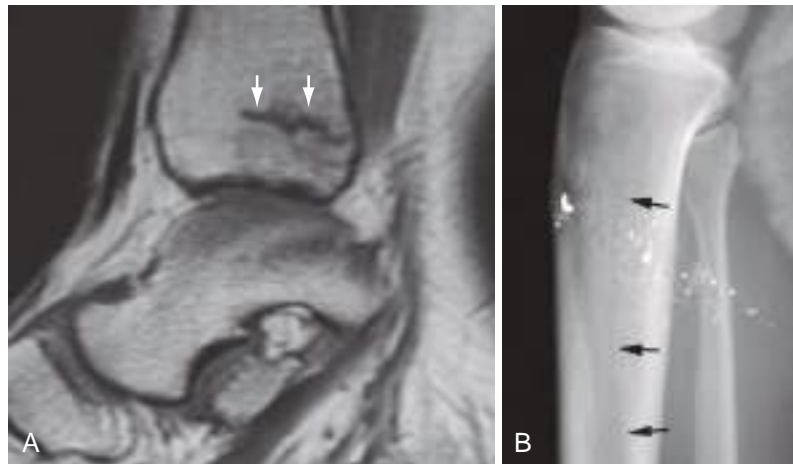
Incomplete fractures in adults. (A) Sagittal T1-weighted MR image shows irregular linear low signal in the distal posterior tibia (arrows) representing a nondisplaced, incomplete trabecular fracture, in this case caused by impactation. (B) Incomplete tibial fracture in an adult (arrows) because of a gunshot wound. Note the metal fragments that mark the bullet tract.
